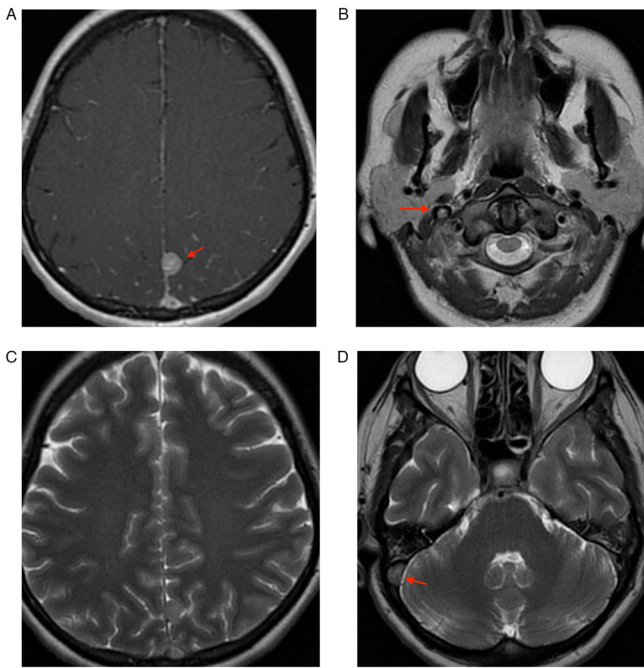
Case 2. On the 4th day of hospitalization, the patient underwent native cranial cerebral magnetic resonance imaging and a venous/segment angiography, examination indicated (A) small left parasagittal superior parietal meningioma (T1-red arrow); (B) thrombosis on transverse sinus on the right side, partially the right internal jugular vein (red arrow); (C) small left parasagittal superior parietal meningioma (T2); (D) thrombosis in the right superior frontal subacute cortical tardive-vein, superior sagittal sinus, sinuses confluent, sigmoid sinuses (right-red arrow).
